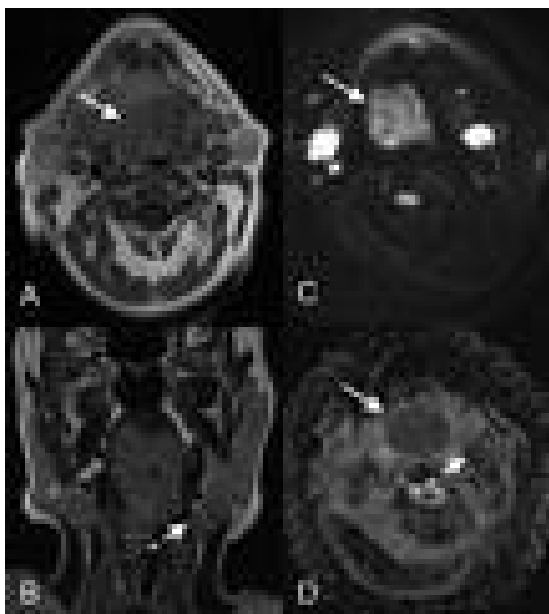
Oropharyngeal cancer (centered on the base of the tongue, white arrows) and ADC map. Conventional MRI sequences (T1 and T2 weighted images, respectively A and B), diffusion image (C) and ADC map (D). Hypercellularity of the lesion means low signal on ADC map. Also nodes (dashed arrows) are clearly depicted (B and D).
